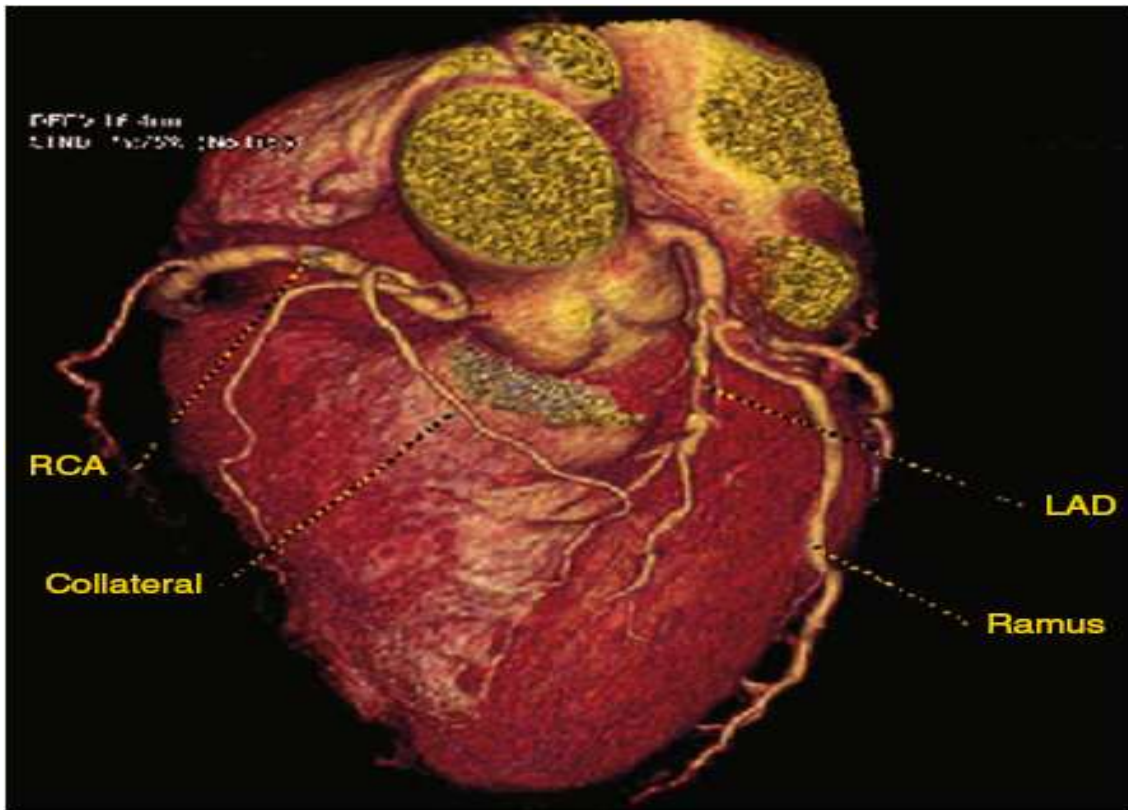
A contrast-enhanced CT of the coronary arteries, with excellent visualization of a high grade stenosis in the mid-portion of the LAD.
